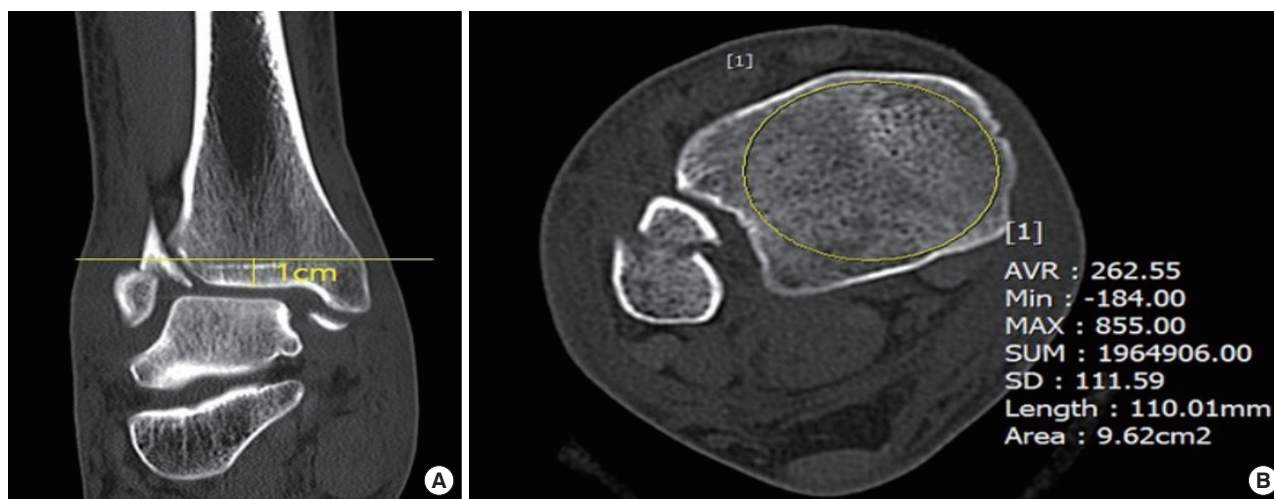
(A) Method for determining the Hounsfield units at the distal tibia metaphyseal region approximately 1 cm proximal to the plafond on computed tomography axial images. (B) The Hounsfield unit was calculated elliptical region of the distal tibia. AVR, average; Min, minimum; MAX, maximum; SUM, summation; SD, standard deviation.
